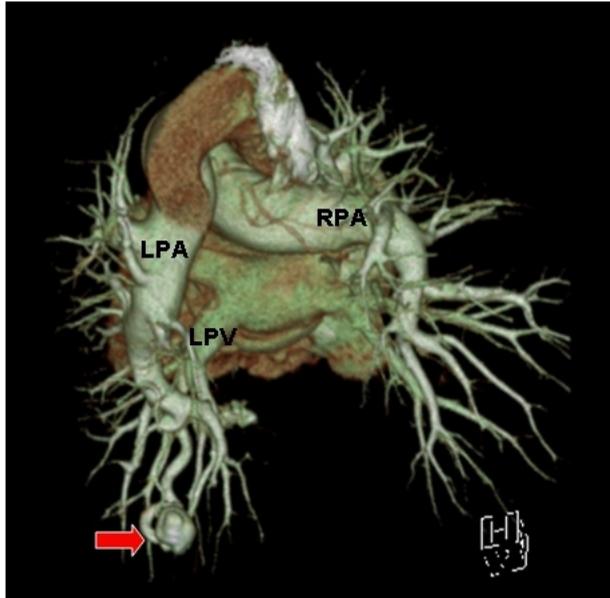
Three-dimensional images of a left lower lobe pulmonary arteriovenous malformations evaluated with spiral CT. Pulmonary arteriovenous malformations consisting of a single feeding artery (arrow) and a single draining vein (arrowhead), both connected to the aneurysmal sac (open circles).
